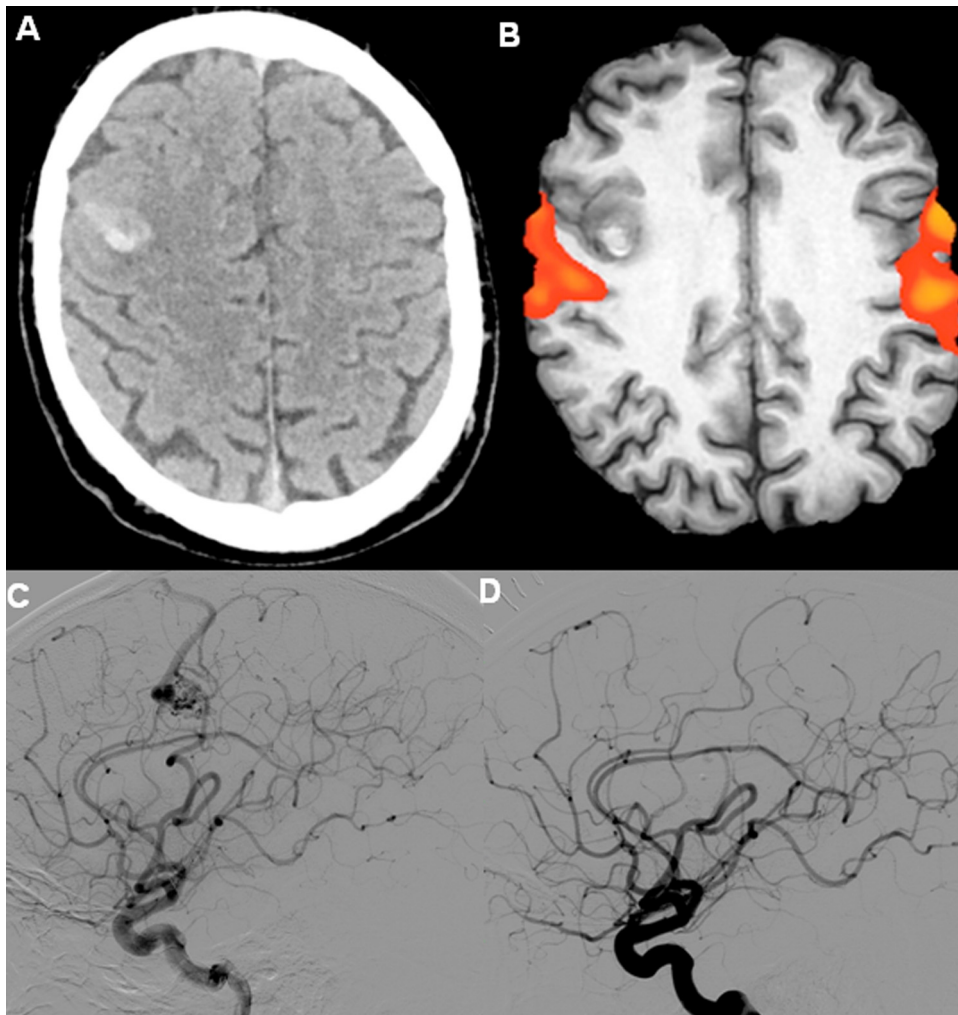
Patient with right precentral rAVM. (A) Preoperative axial CT scan demonstrated a precentral right rAVM. (B) Preoperative brain functional MRI showing motor area behind the rAVM. (C) Preoperative cranial angiography with precentral feeding artery in the rAVM and sagittal sinus venous shunt. (D) Postoperative cranial angiography without remnant.
